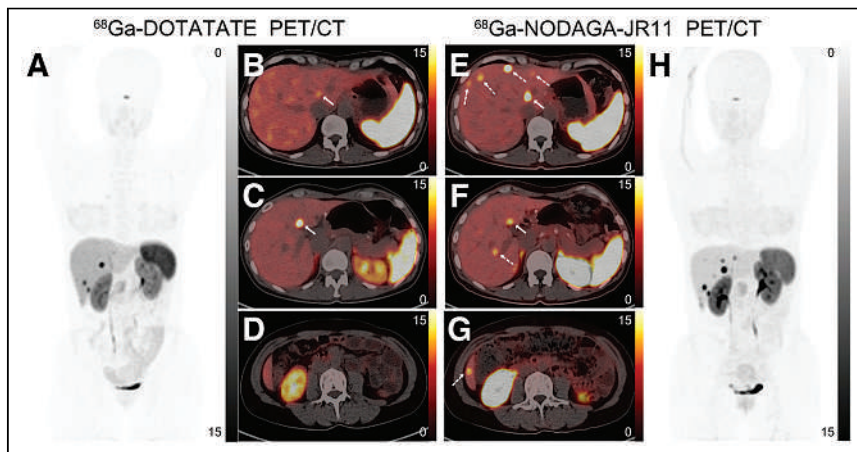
Lesion-based comparison of lesion detection. ^{68}Ga -DOTATATE and ^{68}Ga -NODAGA-JR11 PET/CT images are shown of postoperative gastric NET patient (patient 36) with multiple liver metastases. (A) ^{68}Ga -DOTATATE maximum-intensity projection shows several liver lesions with high uptake. (B) Transaxial fusion image appears to show abnormal moderate-uptake lesion (arrow) in high liver background uptake. (C and D) One transaxial fusion image (C) shows liver metastasis (arrow), whereas no liver lesion was found in another (D). (H) ^{68}Ga -NODAGA-JR11 maximum-intensity projection shows many more liver lesions than ^{68}Ga -DOTATATE. (E–G) Transaxial fusion images at same 3 levels as in B–D similarly found liver lesions that matched those on ^{68}Ga -DOTATATE (solid arrows). ^{68}Ga -NODAGA-JR11 PET/CT shows lower liver background uptake and additional liver metastases (dashed arrows) at sites that were negative on ^{68}Ga -DOTATATE PET/CT.
